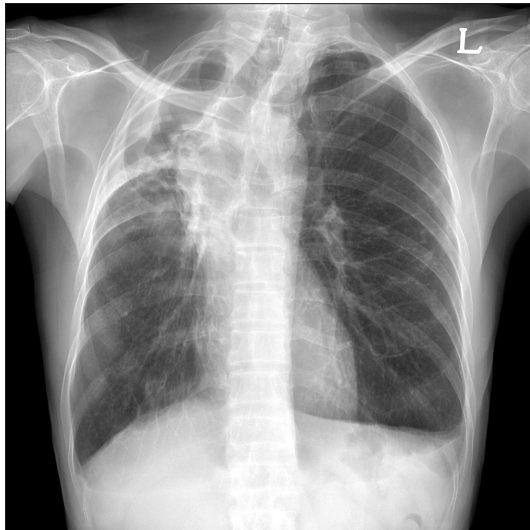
Chest X-ray taken 7 years earlier showing parenchymal destruction, fibrotic lesions, and bullous changes in the right upper lung field caused by a previous episode of pulmonary tuberculosis.
